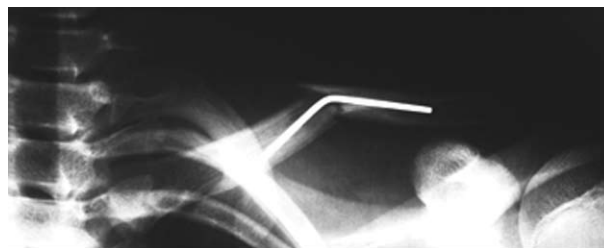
A 16-year-old boy injured in traffic accident as a motorcycle driver. First follow up x-ray on day 7 after open reposition and intramedullary placed K-wire with 1.5 mm radius.
